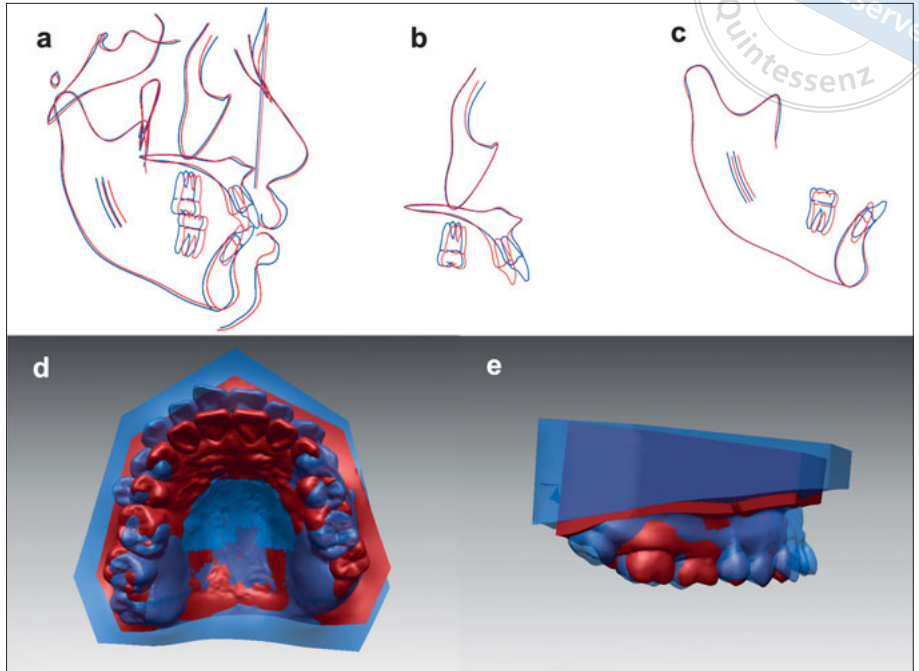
to e Pre- and post-treatment superimposition. Anterior skull base, maxillary, and mandibular superimposition of cephalometric radiographs (a to c). Top and side views of 3D digital model superimposition, pretreatment (blue) and post-treatment (red) (d and e).
